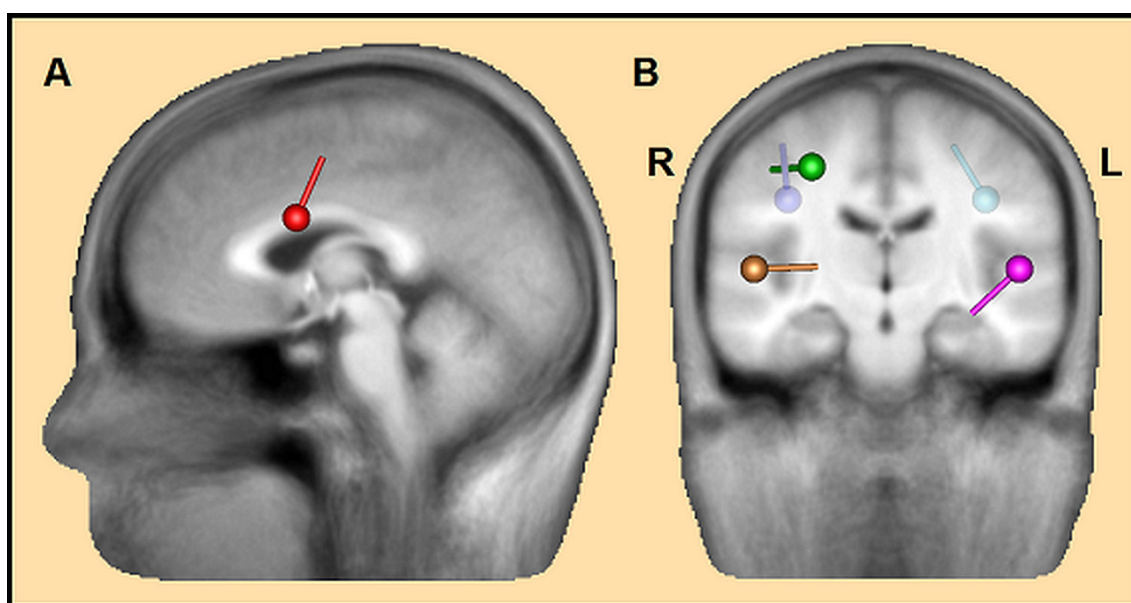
Seven-dipole source model generated from the grand average deviant waveform in *Study 1*. Dipole model is presented in an average MRI provided in BESA in sagittal (A) and verticofrontal (B) planes. Six dipoles are visible in these depicted planes, one dipole accounting for eye movement activity is not visible here. SD1 = red, SD2 = light purple, SD3 = green, SD4 = magenta, SD5 = brown and SD6 = blue. (Figure as originally published in Hautasaari et al. 2017).
